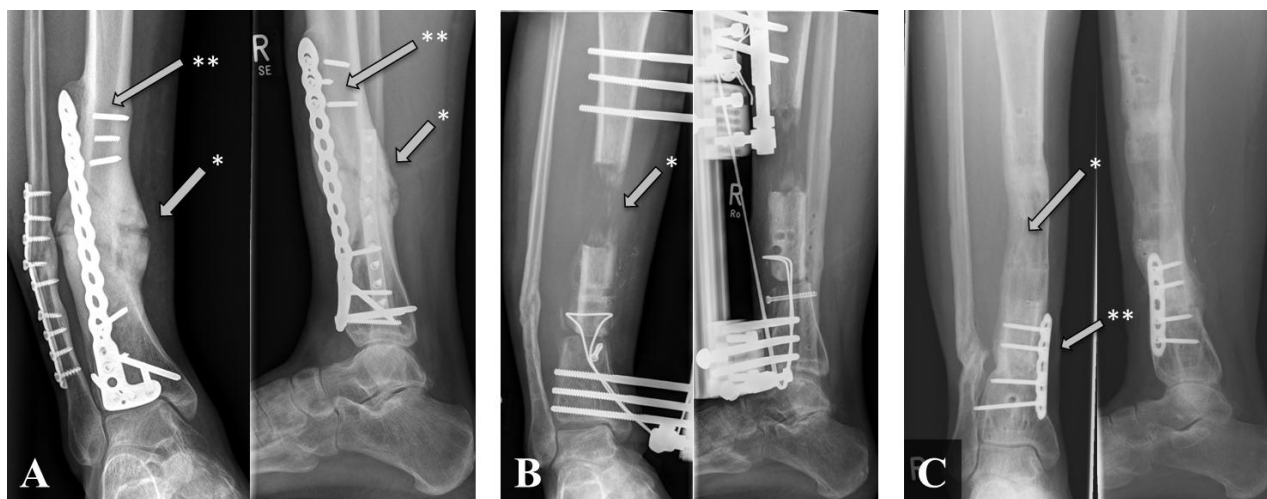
Radiographic documentation of a surgically fixed fracture of the lower leg that failed to heal due to *S. epidermidis* infection. A) Plain x-rays (anterior-posterior and lateral view) show the non-union of the fracture (*) due to *S. epidermidis* infection with secondary displacement and screw failure () 10 months after surgery. B) The infection and non-union required plate removal and resection of necrotic bone leaving a 4cm defect in the bone (*). The defect was treated with segmental bone transport using an external fixator. C) Complete consolidation of transport segment (*) and docking site () required multiple surgeries and an overall treatment period of three years. Anonymized radiographs from a patient with *S. epidermidis* FRI obtained from Trauma Center BGU Murnau (Germany).
